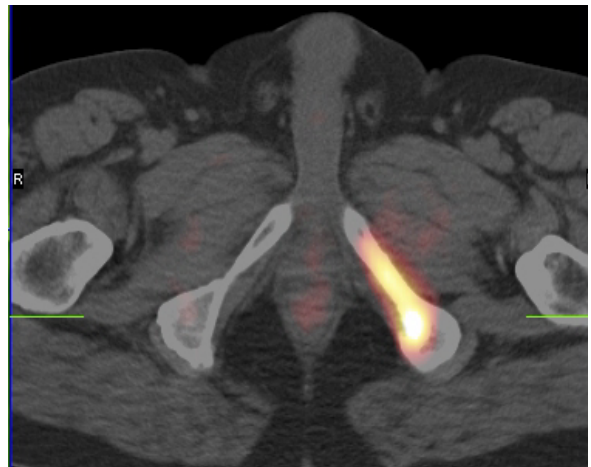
$[^{18}\text{F}]\text{FECh}$ PET/CT: detection of a previously unknown bone metastasis in the pelvis. The patient was originally planned for radical prostatectomy.
